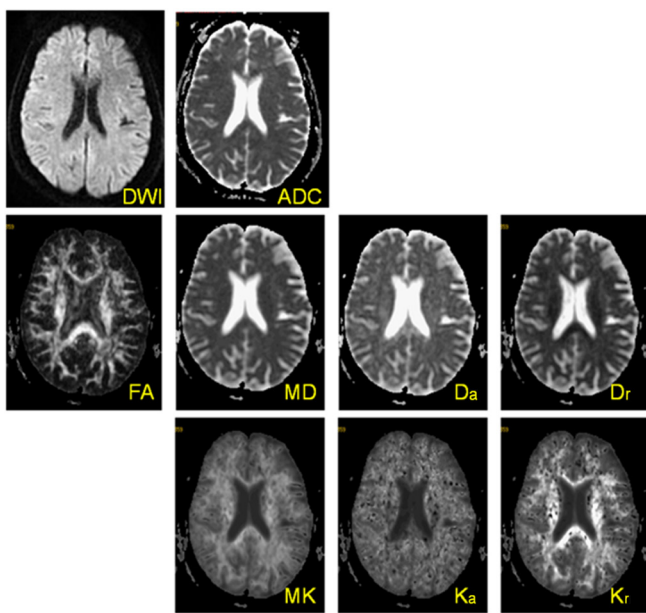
DWI and DKI metrics maps from a 46-year-old healthy female volunteer.
